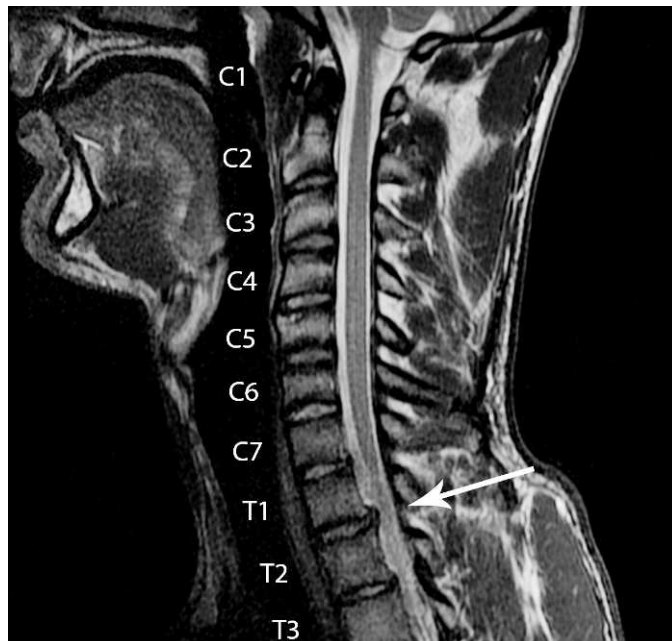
T2-weighted sagittal magnetic resonance image shows an intervertebral disc herniation at the T1–T2 level (arrow).
